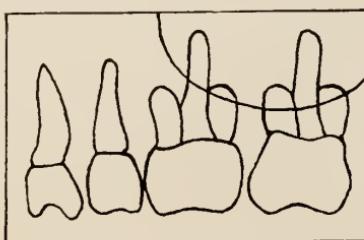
The distal in Figure 3 is to the right. The antrum and shapes of the teeth indicate an upper jaw. We can call this a radiograph of the upper right bicuspid and molar region.
